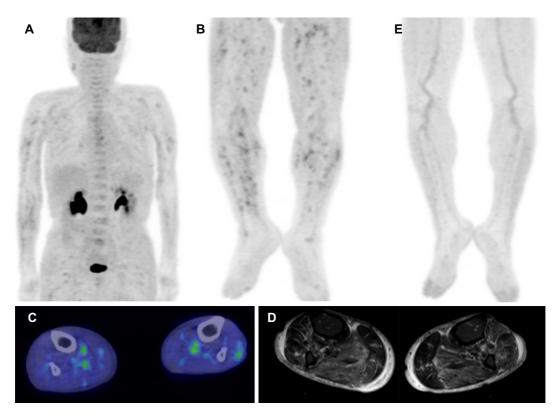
Clinical findings of Case 3. (A-C) Fluorodeoxyglucose-positron emission tomography (FDG-PET) findings at the first evaluation. No significant FDG uptake was observed in the trunk or upper limbs (A), while multiple patchy uptakes in the lower limbs were noted (B). (C) FDG-PET/ computed tomography in the thighs showed an increased FDG uptake in the crural muscles. (D) Magnetic resonance imaging with a short T1 inversion recovery sequence revealed a diffuse high intensity in the femoral muscles. (E) FDG-PET showed the significant resolution of the patchy uptake in the lower limbs after treatment.
